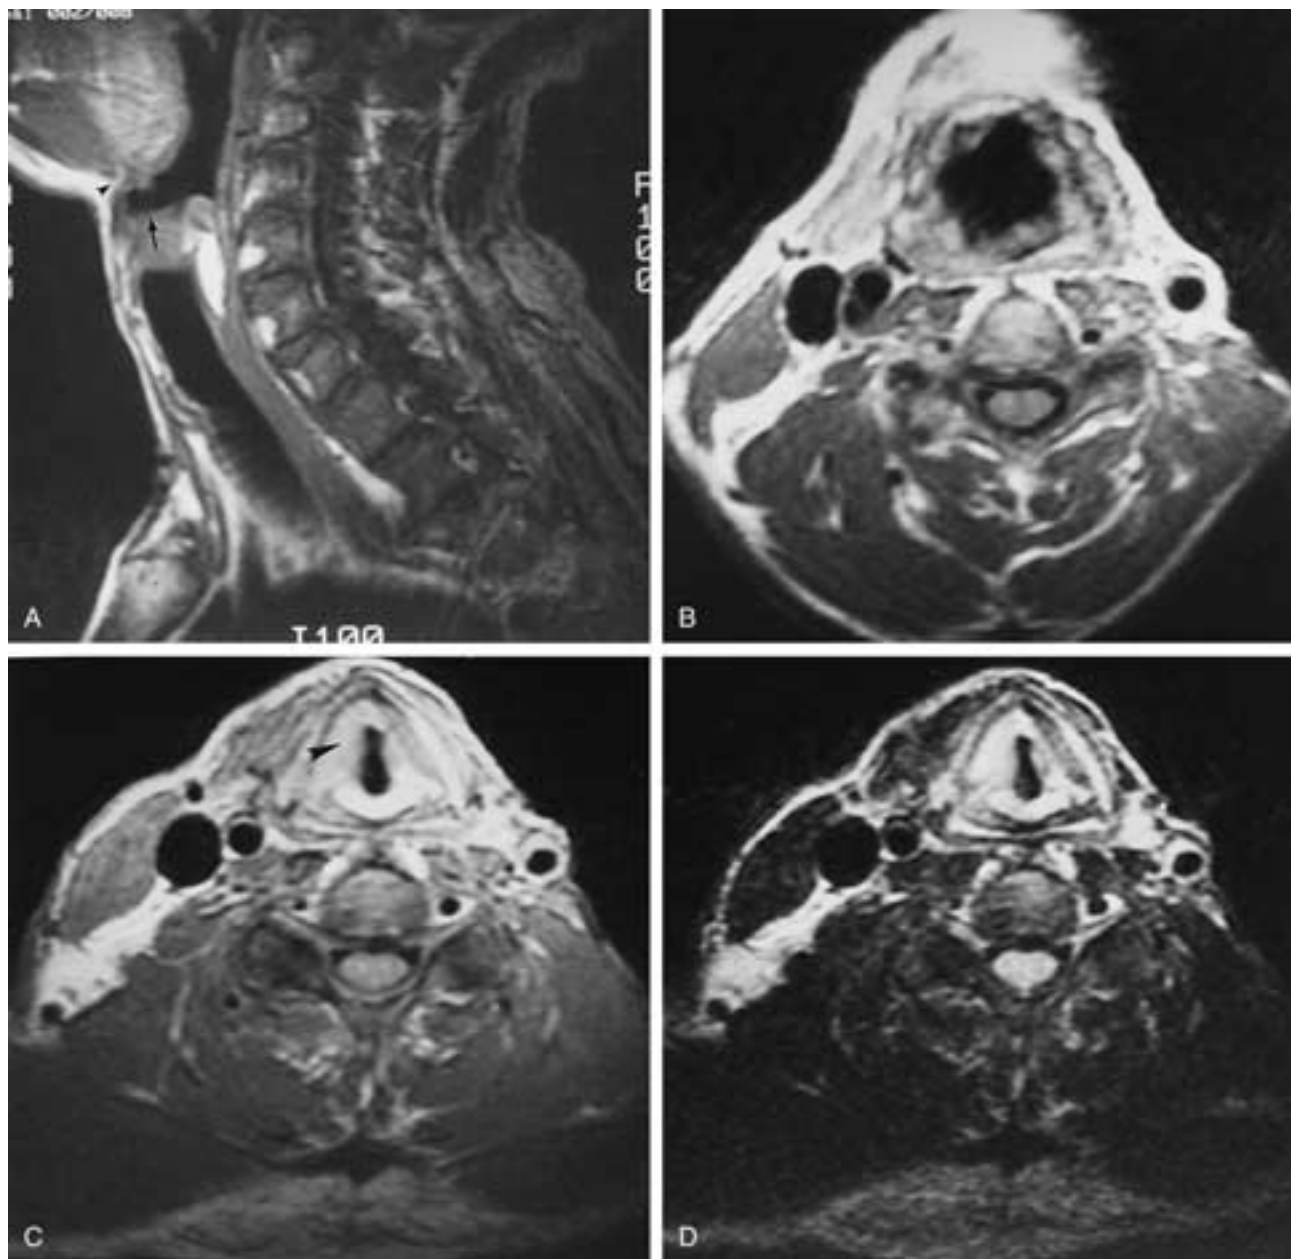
MR image of a supraglottic laryngectomy with recurrence at the cord level. A, Sagittal T1-weighted image shows the absence of supraglottic structures including the epiglottis. The upper margin of the larynx has taken on a rather square appearance (*arrow*). The larynx has been sutured to the base of the tongue and the mylohyoid (*arrowhead*). B, Axial T1-weighted image at the supraglottic level shows the irregular appearance of the supraglottic defect above the cord. C, Image shows thickening of the involved cord (*arrowhead*). D, T2-weighted image shows brightening of the involved cord. This could be from tumor or from edema. In this case it represented recurrence.
